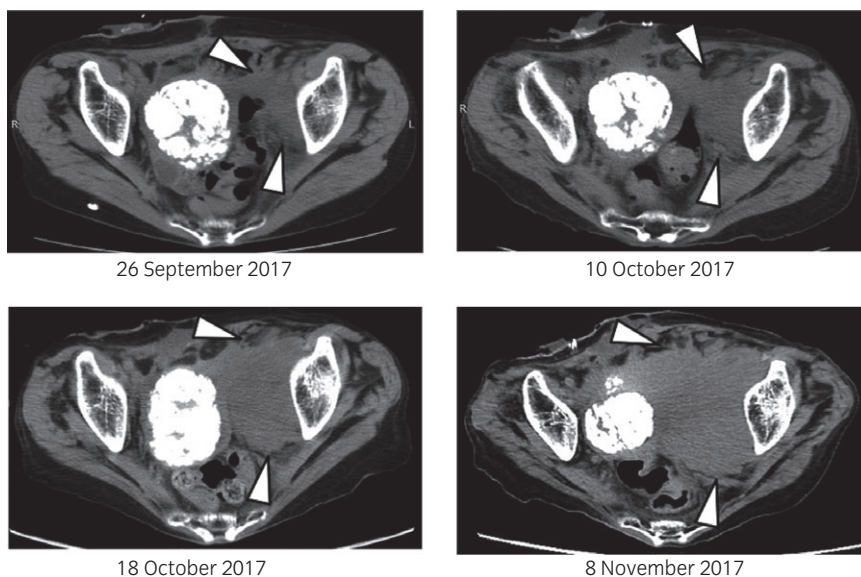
CT scan taken at the indicated time points. Soft tissue mass on the left pelvic side (indicated by arrowheads) was rapidly progressing.
